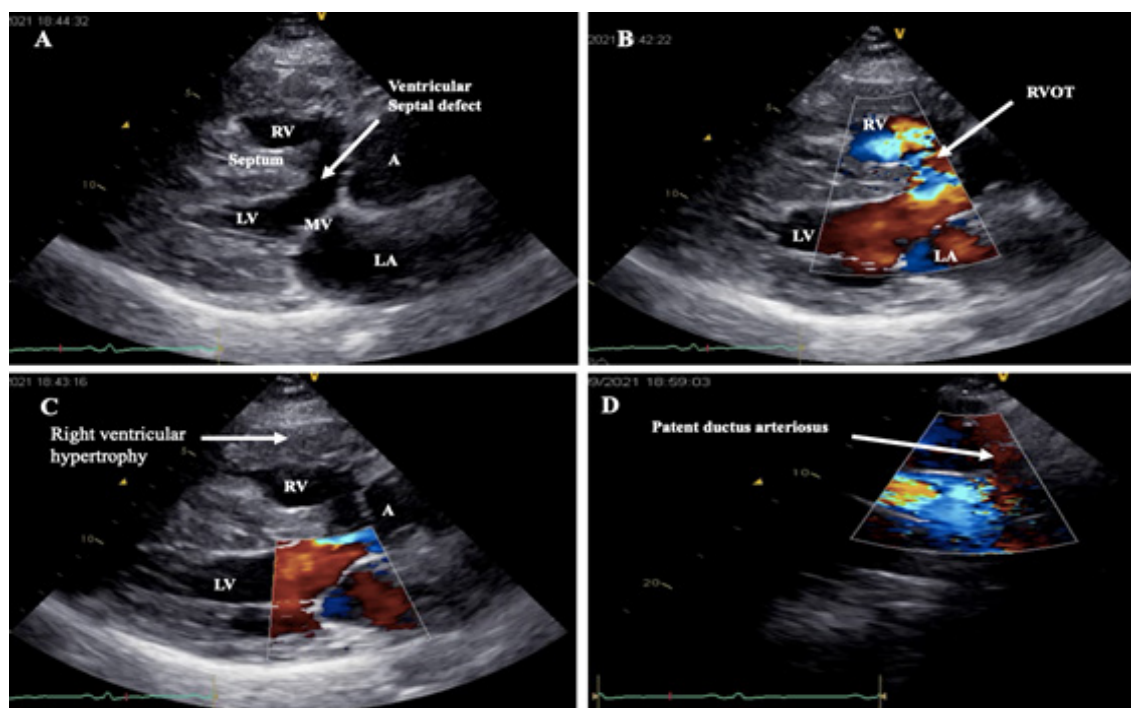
Echocardiogram, A) Paraesternal long axis, interventricular septal defect with aortic overlap (white arrow); B) Bidirectional shunt of left-right predominance, right ventricular outflow tract (white arrow); C) RVH (white arrow); D) PDA (white arrow). RV: right ventricle; AA: aortic artery; LV: left ventricle; LA: left atrium; MV: mitral valve; RVOT: right ventricular outflow tract
